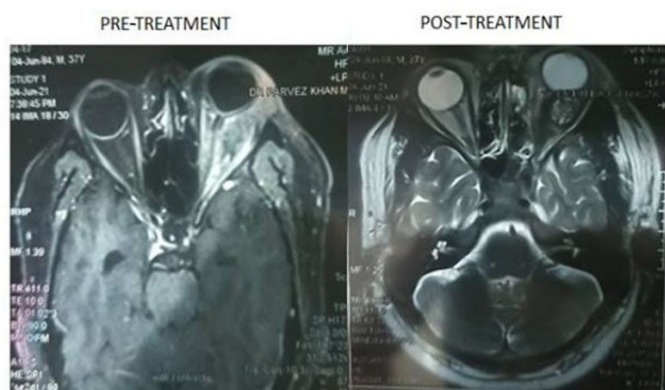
Pre-treatment—T1-weighted axial MRI shows left isointense signal intensity lesion, involving intraconal and extraconal spaces, extending along orbital apex. Post-treatment—T1-weighted axial CEMRI shows decrease in hyperintensity of the extraocular muscles and proptosis of left eye after treatment of mucormycosis.
